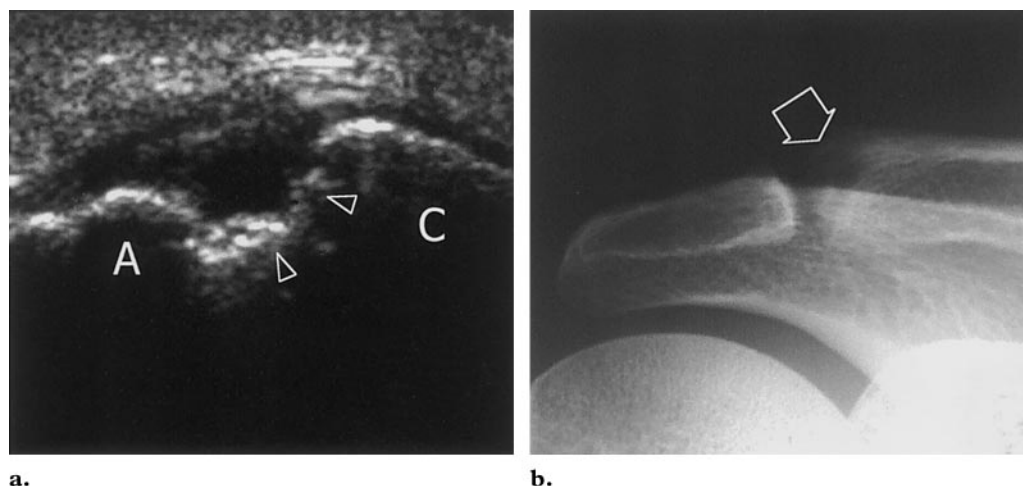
Posttraumatic osteolysis of the clavicle in a 25-year-old man with a 6-month history of posttraumatic pain and tenderness over the ACJ. (a) Coronal 10–5-MHz US image demonstrates irregular erosion (arrowheads) of the distal end of the clavicle (C). A = acromion. (b) Radiograph helps confirm the presence of osteolysis (arrow).
